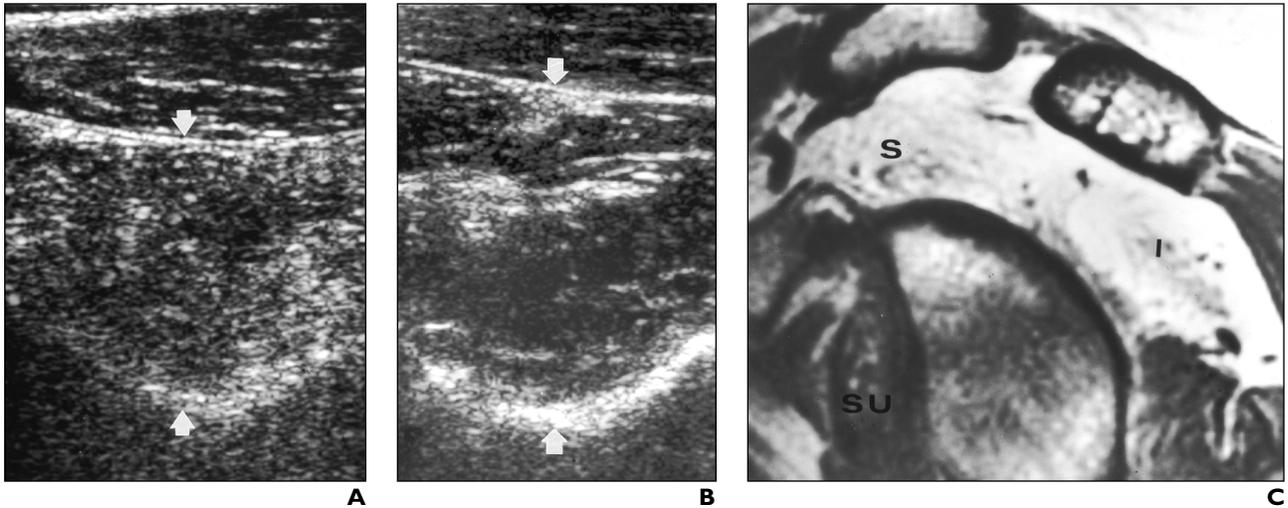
47-year-old woman with longstanding brachial neuritis (Parsonage-Turner syndrome). A, Longitudinal 5-12-MHz sonogram shows increased echogenicity within atrophic right infraspinatus muscle (*arrows*), caused by denervation. B, Sonogram shows normal echogenicity on contralateral side at same magnification (*arrows*). C, Sagittal oblique T1-weighted image (TR/TE, 500/14) of same shoulder as in B shows atrophy and fatty infiltration of infraspinatus (I) as well as supraspinatus (S) muscles. Subscapularis (SU) muscle bulk is normal.
